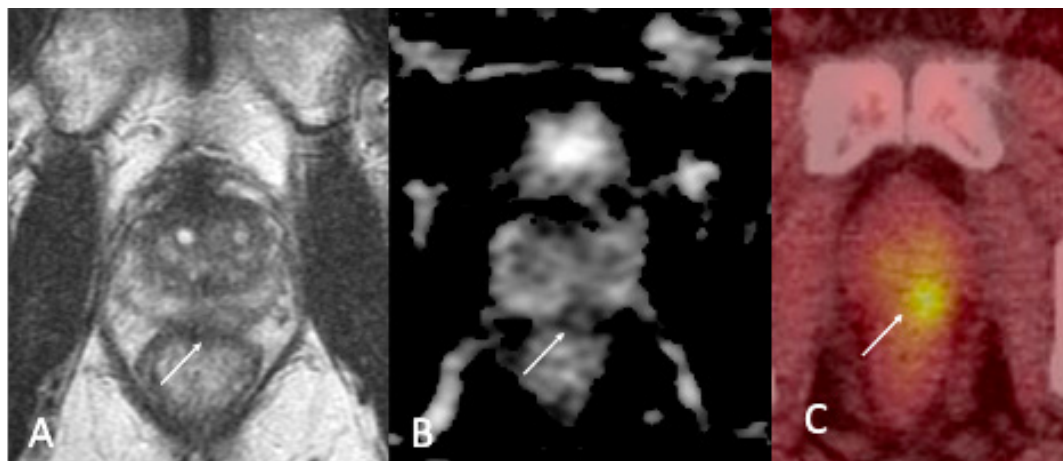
Prostate MRI: (A) axial T2 image, PI-RADS 5 lesion, prostate volume 30 cc. (B) apparent diffusion coefficient (ADC) map with corresponding region of restricted diffusion. (C) fluciclovine F 18 prostate-specific membrane antigen (PSMA) PET demonstrating uptake in the left posterior prostate. SUV 7.2.
